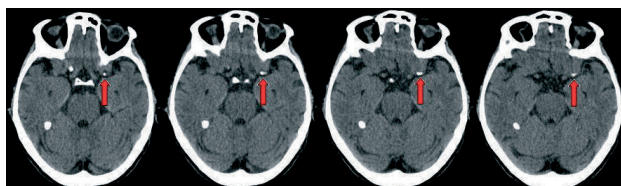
CT scan on admission. The arrows show endoluminal hyperdense calcification in the M1 segment of the left middle cerebral artery.
